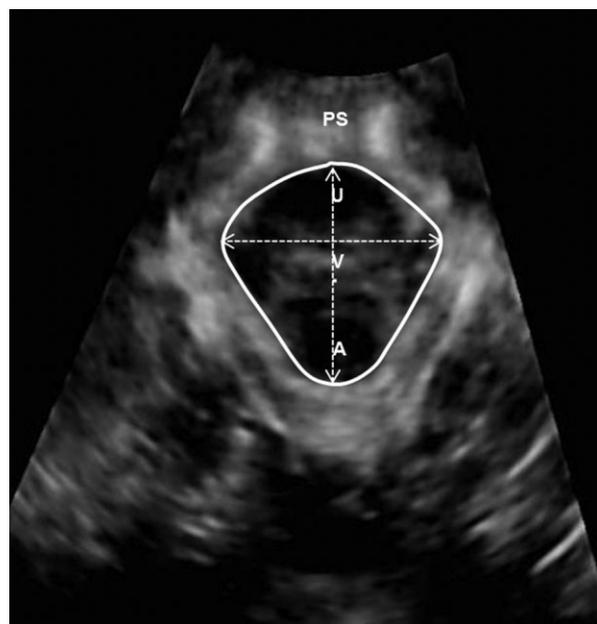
Axial plane produced by transperineal ultrasound at rest.
